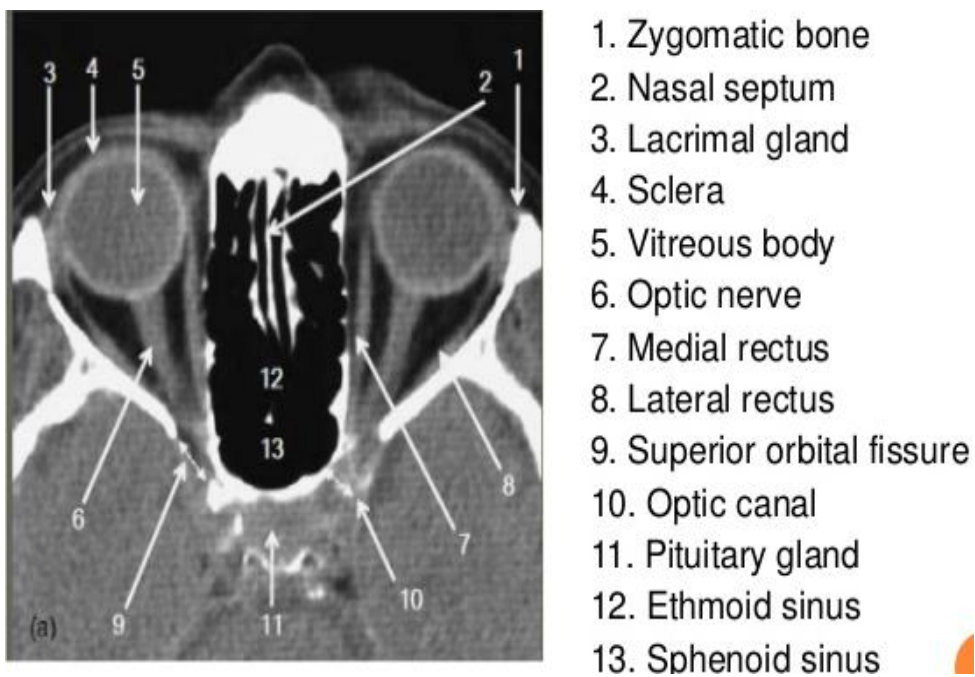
CT Orbit Axial view
